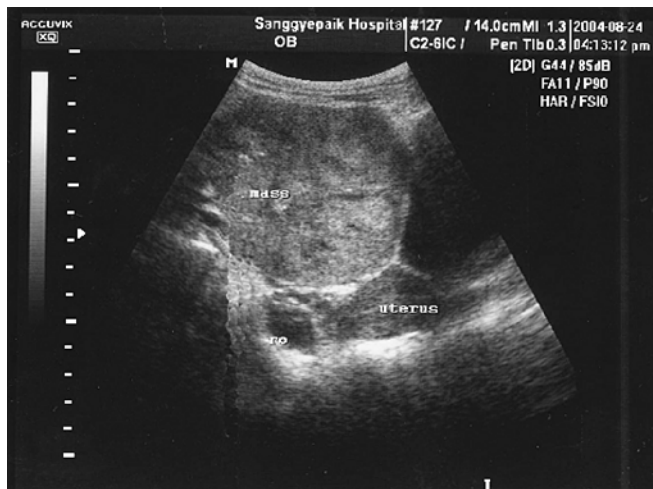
Abdominal sonogram demonstrates a solid mass at the right broad ligament, which is anteriorly attached to the right ovary (*ro*)
